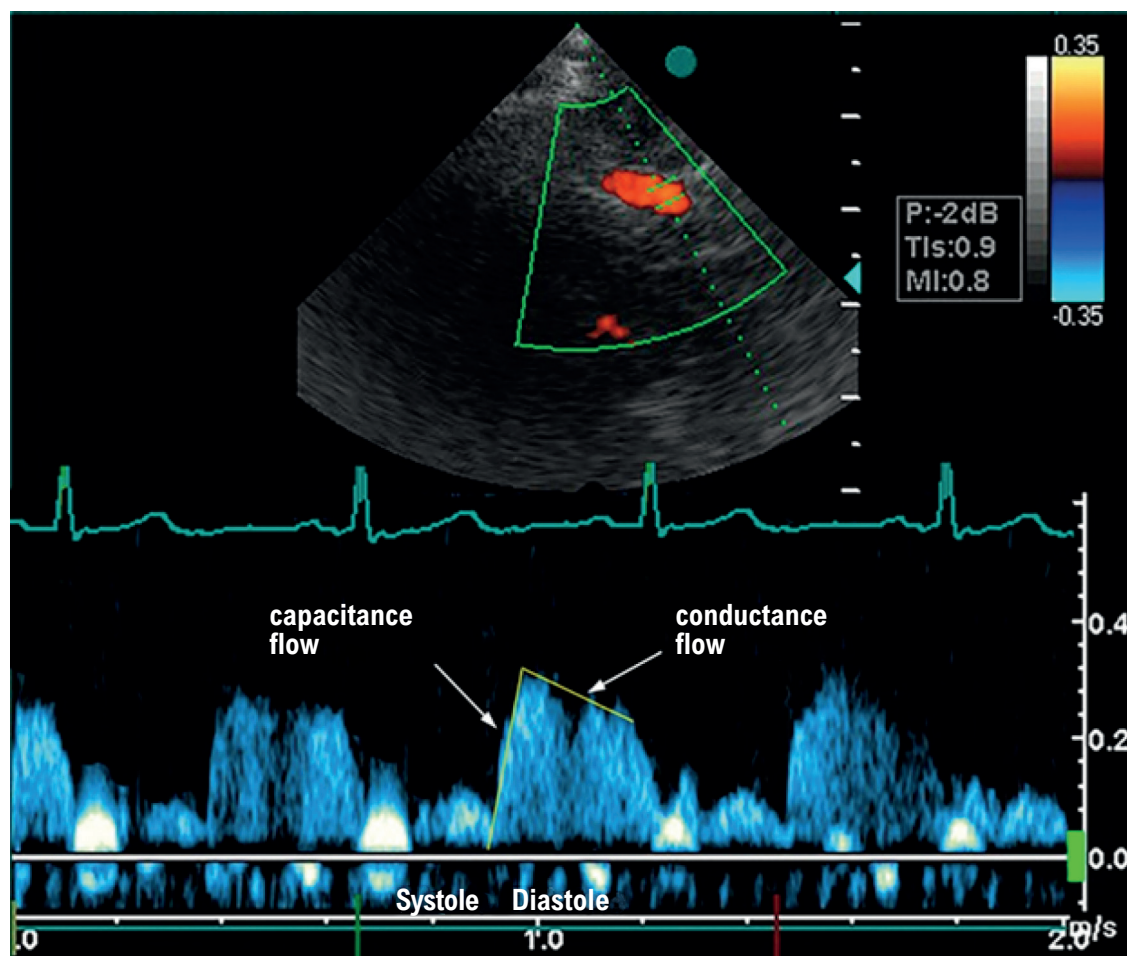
Transthoracic Doppler of coronary flow showing a normal systo-diastolic pattern.
